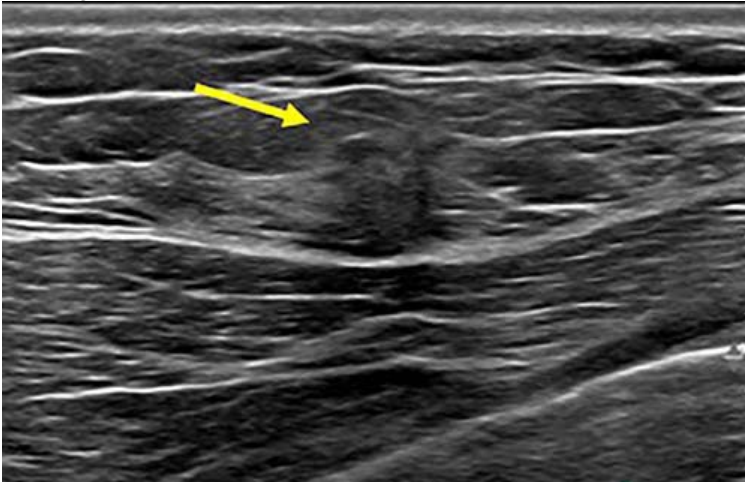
Breast ultrasound image. Area of distortion persisted on additional mammographic views, and a mass is identified on subsequent breast ultrasound. Ultrasound guided biopsy was performed and revealed nuclear grade 1 invasive ductal carcinoma.
